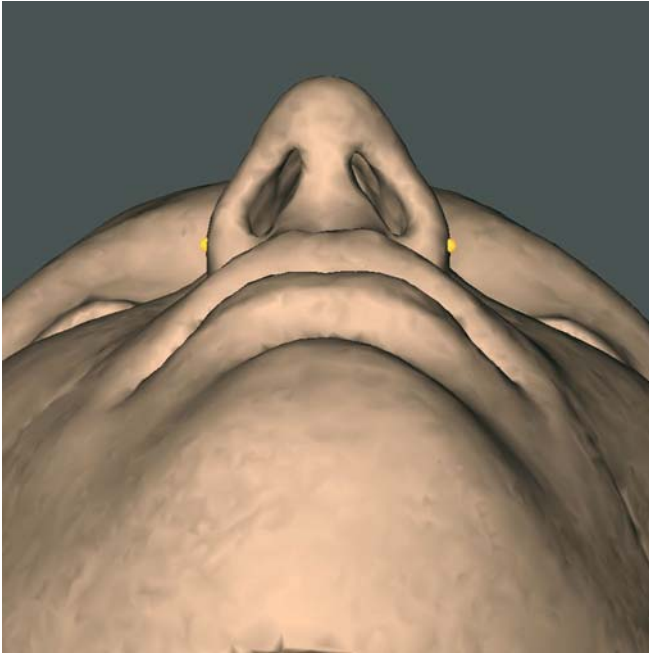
Alare_r and alare_l. Base view (3-D CT, patient K.C.)
